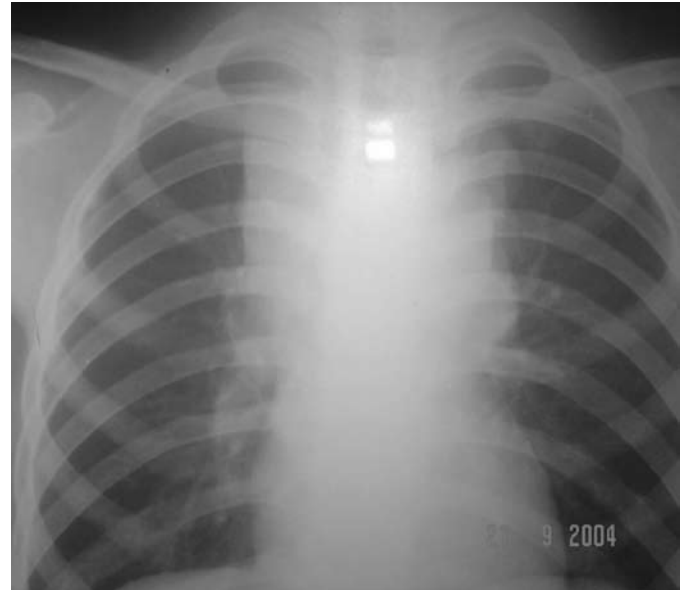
Chest X-Ray showing mediastinal adenitis
